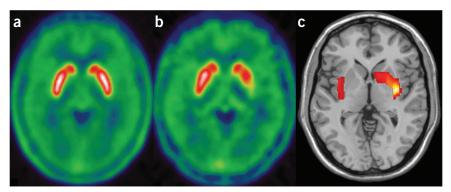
Striatal dopamine innervation assessed by ¹⁸F-dopa positron emission tomography. (a) Mean control values for eight control subjects shows high uptake (highest value in white) in the striatum. (b) Subject with Parkinson's disease (right) featuring slowness and rigidity on the right limbs but minimal signs on the left limbs. Uptake is markedly reduced (70% below normal) in the left posterior putamen and reduced to a minor extent in the anterior putamen and caudate of the left hemisphere. (c) SPM2-based analysis (yellow represents the largest statistical difference and red the smallest one), showing the difference in uptake between a and b to highlight the caudorostral pattern of denervation. The statistical map is rendered over the MRI for anatomical localization.
